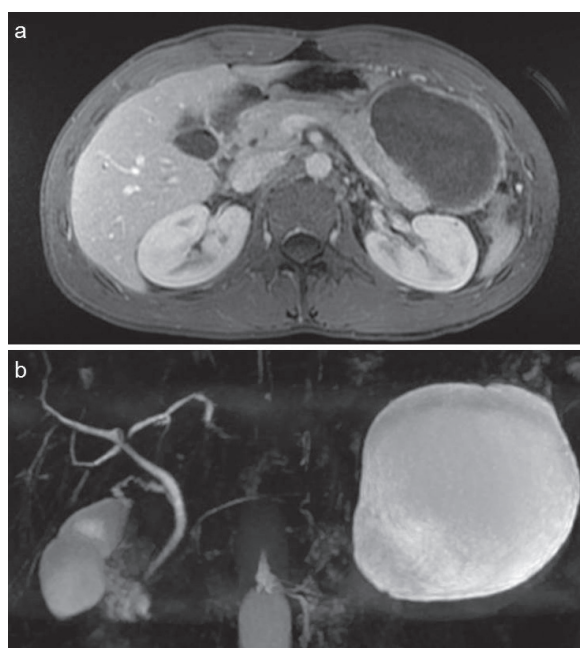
Imaging findings of a case of cannabis-induced acute pancreatitis. A 25-year-old male with recurrent episodes of acute pancreatitis (AP). Axial T1-LAVA MRI (a) revealed the presence of a pancreatic pseudocyst measuring 15 cm of diameter with a normal gallbladder and biliary system; the Wirsung duct was not dilated at Magnetic Resonance Cholangio-Pancreatography (MRCP) (b). The patient presented persistent nausea and abdominal pain, so an endoscopic ultrasound (EUS)-guided drainage of the pancreatic pseudocyst was performed, with the placement of two cysto-gastric plastic pigtailed. All the AP episodes were considered idiopathic, as alcoholic, biliary, autoimmune, genetic, and drug-related etiologies were excluded. Yet, after further interviewing the patient, he revealed a daily use of cannabis for recreational purposes. Thus, the diagnosis of cannabis-induced AP was made.
